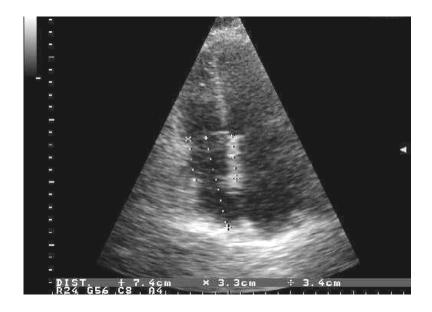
Modified apical four chamber view of transplanted heart with D/R right atrium anterior wall ratio <1
